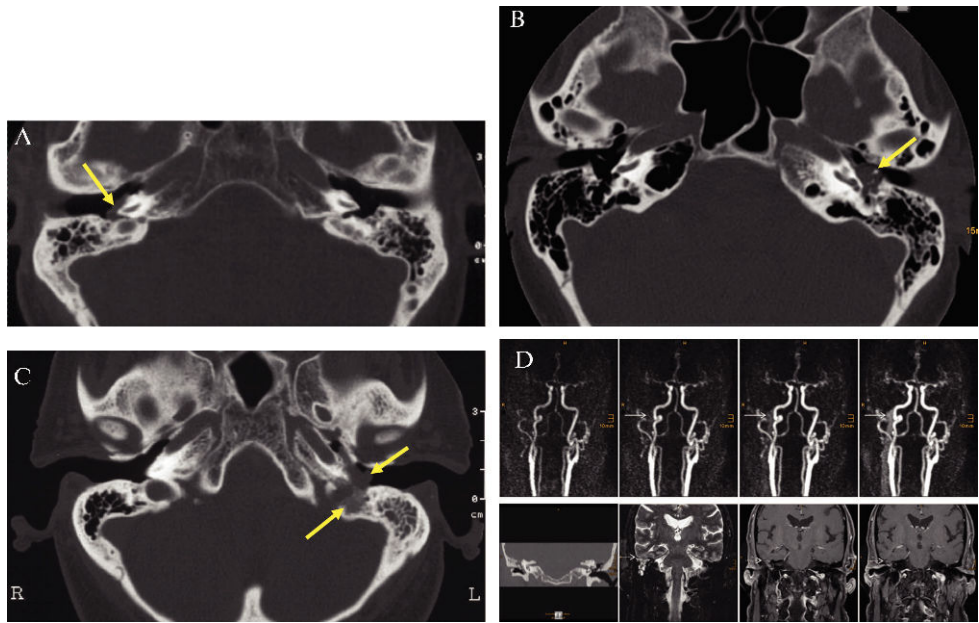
Fisch classification. The tumors are indicated by yellow arrows. (A) Tympanic paraganglioma (Fisch class A): axial CT scan of a tympanic paraganglioma (bone window) on the right promontory. Note the absence of any bony erosion. (B) Tympanic paraganglioma (Fisch class B): the axial CT scan reveals a left-sided tympanic paraganglioma surrounding and partially destroying the ossicles. The malleus and stapes could not be discriminated. The tumor had also invaded the hypotympanon. There was no destruction of the bone wall to the jugular bulb. (C) Jugular paraganglioma (Fisch class C): axial CT scan showing a left-sided jugular paraganglioma. Note the bone destruction between the jugular bulb and the soft tissue tumor in the hypotympanon. (D) Tympanic paraganglioma (Fisch class D): time-resolved contrast-enhanced MR-angiography (upper row) depicts an early venous drainage attributed to arterio-venous fistulas within this tympanic paraganglioma (solid arrows). Coronal CT (lower row left) of the petrous bone shows a soft tissue tumor with encasement of the ossicles within the whole tympanon, and destruction of the tegmen tympani. Coronal T2-weighted and contrast enhanced T1-weighted images show a small, but distinct, intracranial but extradural tumor growth on the lateral skull base (dotted arrows, lower row).
